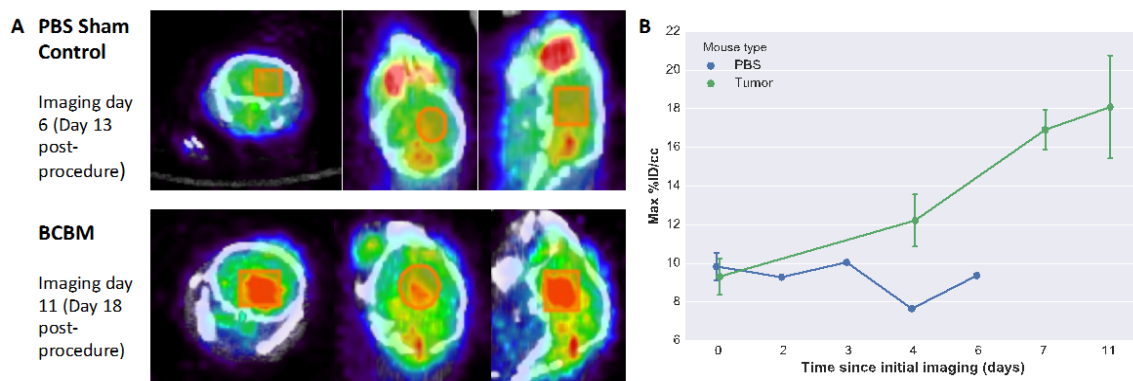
^{18}F FDG uptake over the natural course of BCBM growth. A. axial, coronal, and sagittal fused PET/CT images demonstrating volumes of interest from which statistics were derived using AMIDE. Maximum injected dose per volume measured from VOIs of PET/CT images.
